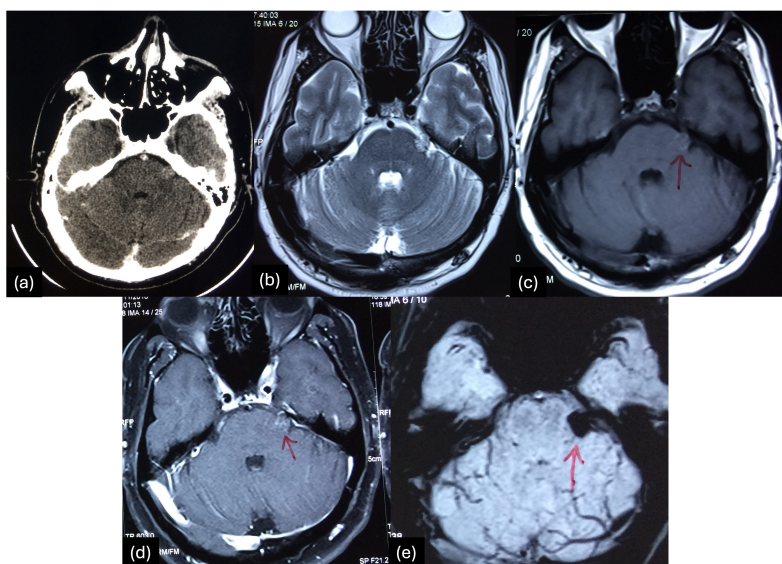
(a) Axial contrast-enhanced CT shows a hyperdense lesion in the left cerebellopontine angle cistern in the path of the left trigeminal nerve cisternal segment. (b) T2W axial image shows a T2 heterogeneous lesion with a T2 hypointense rim in the cisternal segment of the left trigeminal nerve. (c) An axial T1W image shows that the lesion has a mixed signal on T1-weighted sequence. (d) Axial post-contrast T1W image shows no significant enhancement. (e) The GRE axial image shows blooming within the lesion. Imaging features suggest a cavernoma along the left trigeminal nerve.
